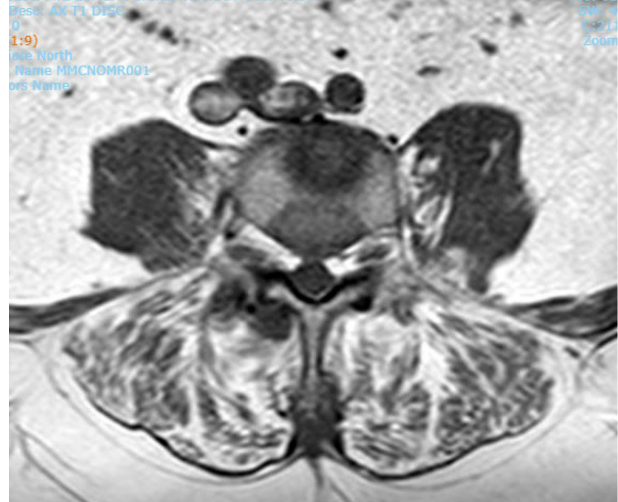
Lumbar spine MRI without contrast in August 2024.
